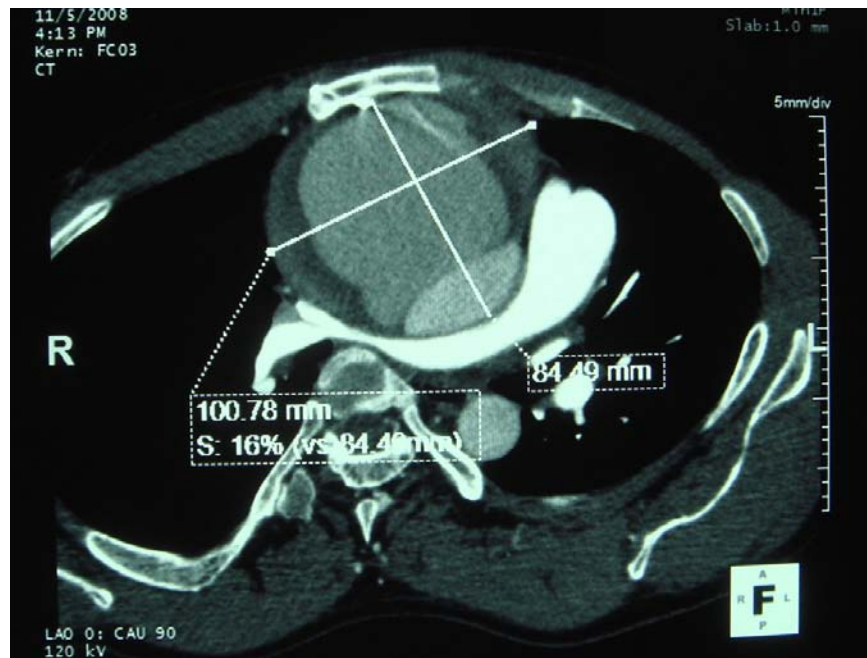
CT cross-sectional image showing a thoracic aortic aneurysm. Aneurysm measurements in its largest section: 84.49 mm x 100.78 mm.
